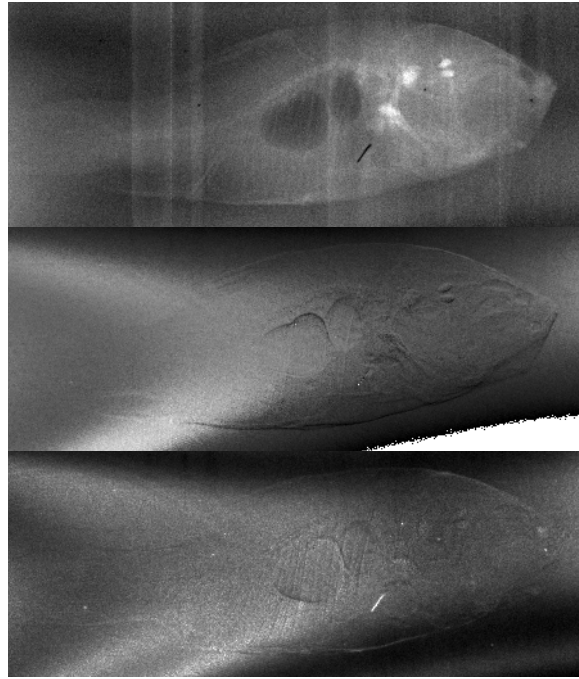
The projection (radiographic) images of a gold fish corresponding to: (a) attenuation contrast, (b) differential phase contrast, and (c) dark field contrast (detector cell: $96\ \mu m$).
